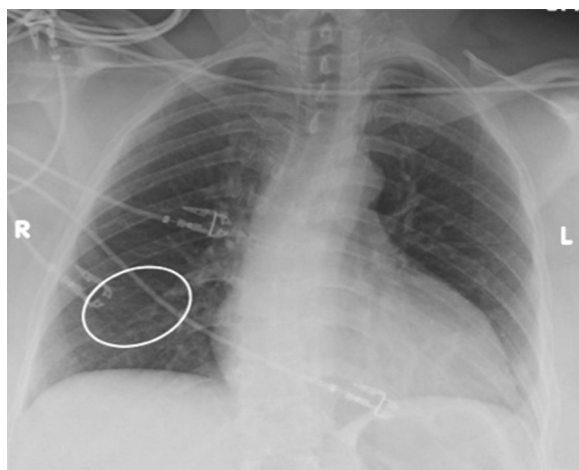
Chest radiograph confirming the presence of the lytic lesion (circle).
